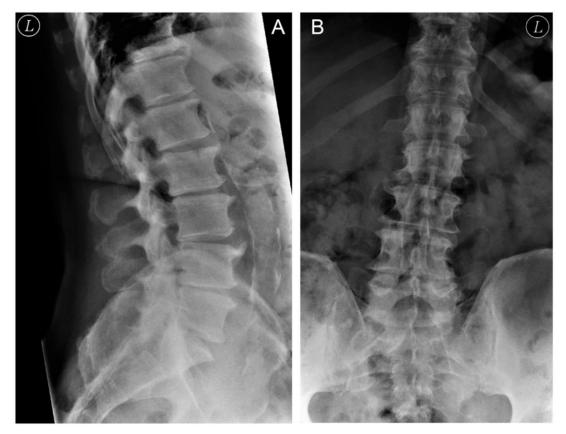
A: X-ray of the lumbar spine sagittal and B: Coronal X-ray of the lumbar spine of the preop patient case profile. (Source: Klinikum rechts der Isar)
